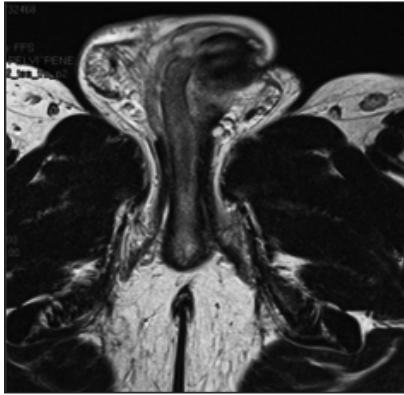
Magnetic Resonance Imaging with gadolinium showing the interruption of tunica albuginea at the level of the proximal third of right corpus cavernosum without urethral involvement.
